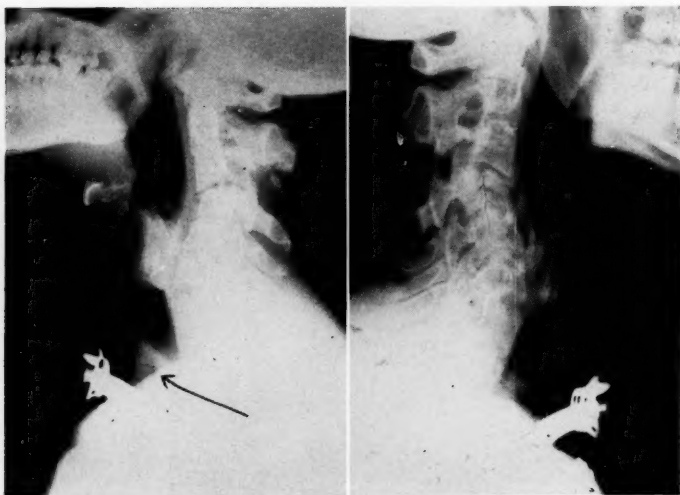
Preoperative lateral neck roentgenogram, showing marked distortion of cervical spine from multiple fractures. Arrow points to proximal end of evulsed trachea.
